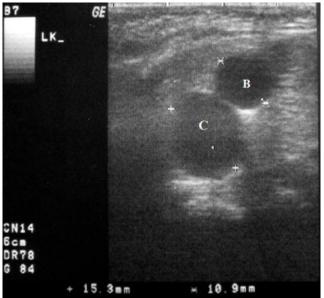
A 3-month-old girl with McKusick-Kaufman syndrome. The mid-sagittal sonographic image shows a hypoechoic cystic structure measuring 15.3 mm (C) posterior to the bladder (B) with fluid-debris level in dependent part.
